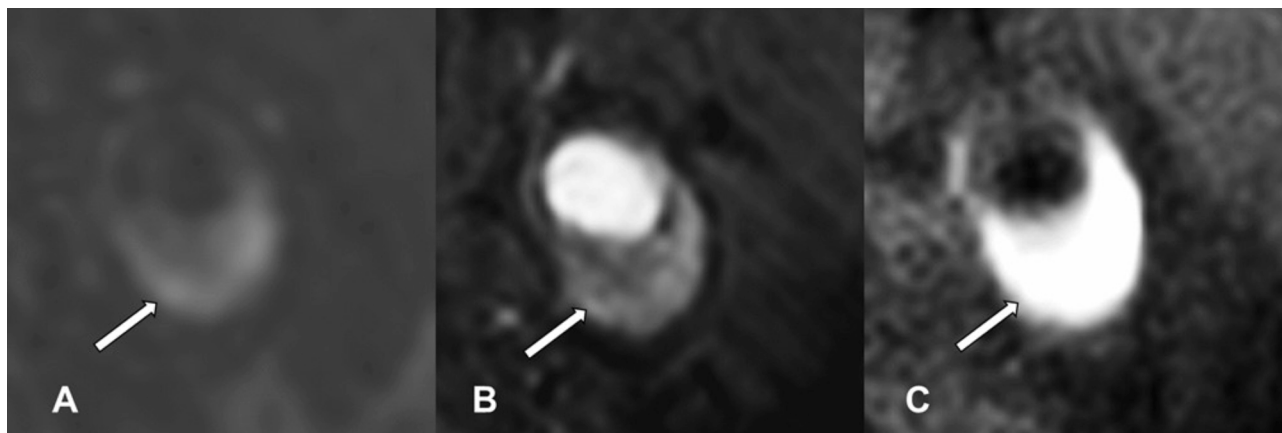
An example of a true positive finding. IPH is shown as a region within the bulk of the plaque with high signal intensity (arrow) on all three MRI weightings: A) contrast-enhanced MR angiography (CE-MRA) mask image, and B) Time-Of-Flight (TOF) and C) Magnetization Prepared-Rapid Acquisition Gradient Echo (MP-RAGE) image.
